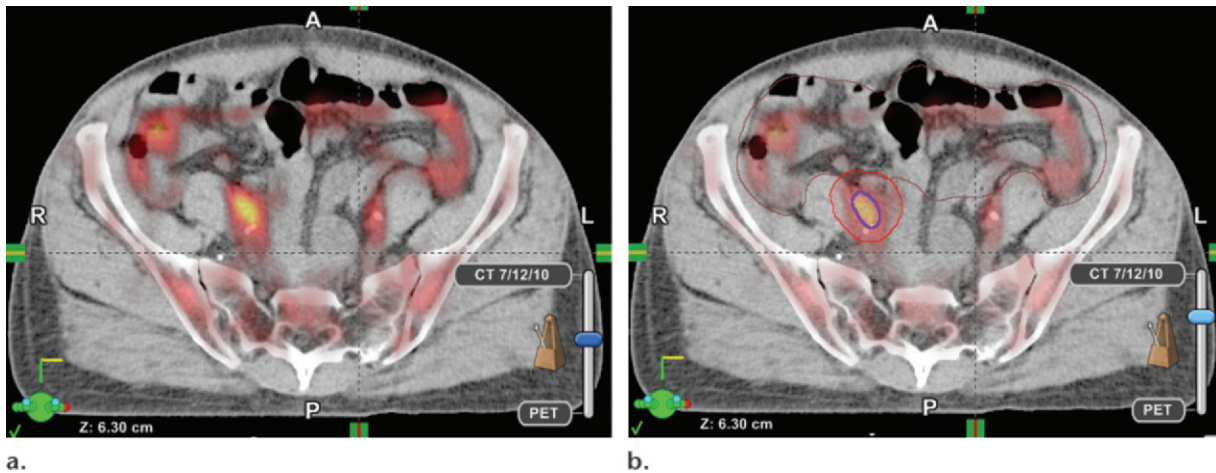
Multimodality imaging–based target delineation in a woman with gynecologic cancer. Axial pelvic CT image acquired for treatment planning is coregistered with FDG PET images (a) to allow the delineation of a hypermetabolic external iliac lymph node, as shown on b (purple contour). This high-precision delineation allows targeting of the involved lymph nodes with a higher radiation dose.
